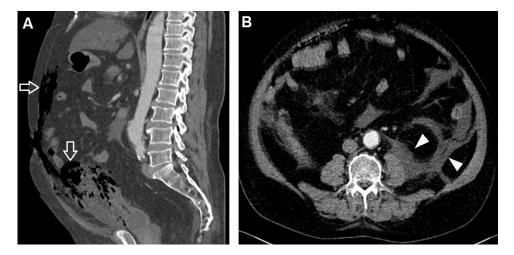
Coronal abdominal CT image showing multiple gas foci in the extraperitoneal space (A, arrows). Axial abdominal CT image showing extraperitoneal fluid (B, arrowheads).
